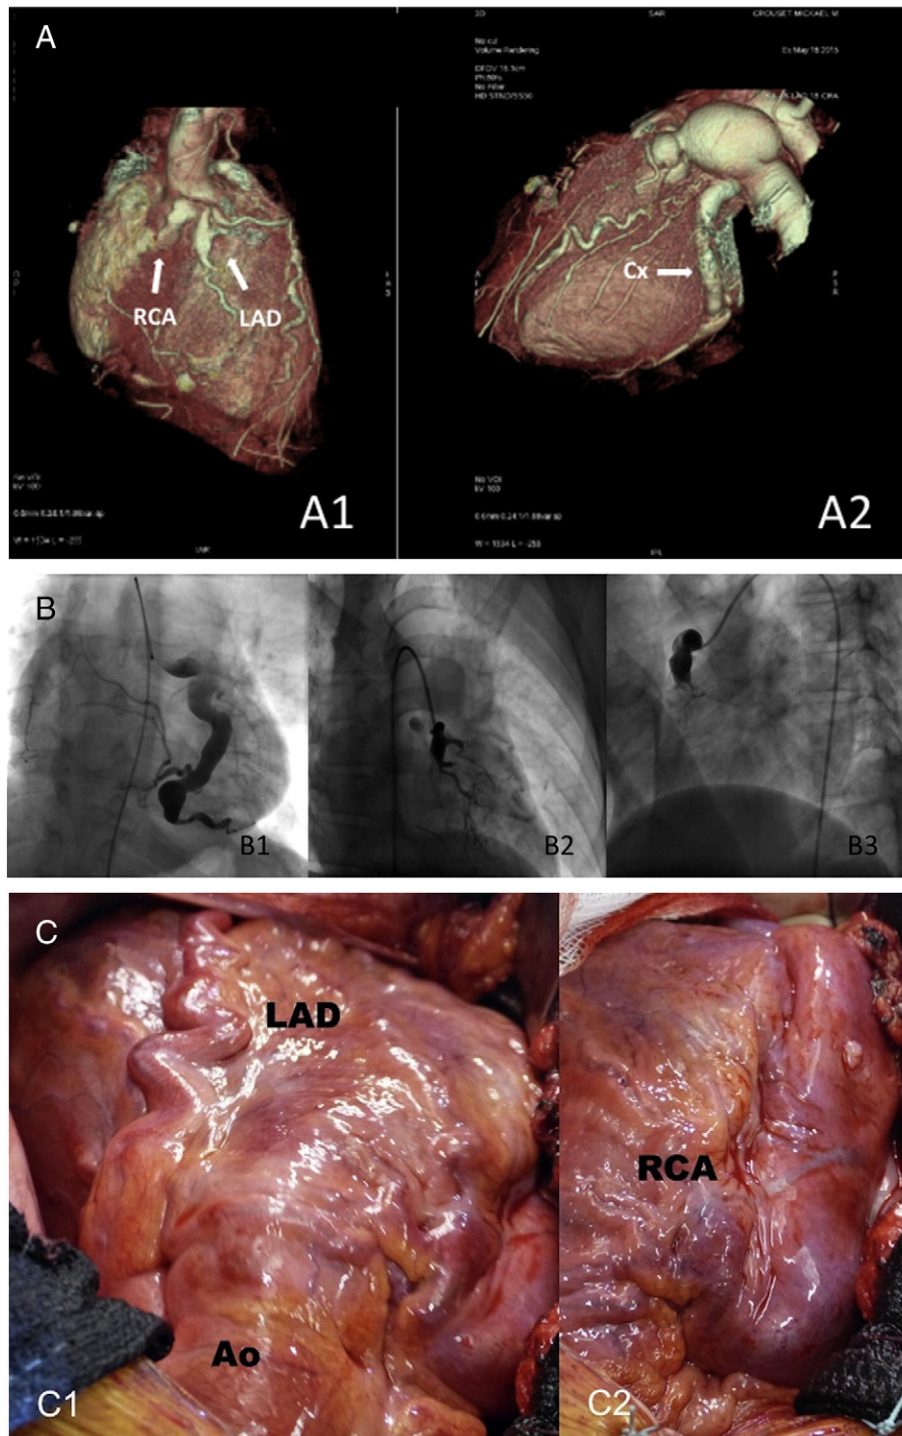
A. CT coronary angiogram. A1: Left anterior descending (LAD) and right coronary artery (RCA) dilated at their origin and occluded at their proximal segment. A2: Aneurysmal circumflex artery (Cx). B. Invasive coronary angiography. B1: Aneurysmal circumflex artery (Cx). B2: Left anterior descending artery (LAD) ectatic at its origin and occluded at its proximal segment. B3: Right coronary artery (RCA) with a dilated origin and an occluded proximal segment. C. Intraoperative view of ectatic coronary arteries. C1: Left anterior descending artery (LAD). C2: Right coronary artery (RCA).
